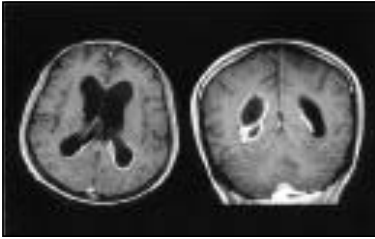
An MRI sagittal and coronal sections of T-1 weighted image with contrast showing ventricular dilatation with intense enhancement of the ventricular lining consistent with ventriculitis.
